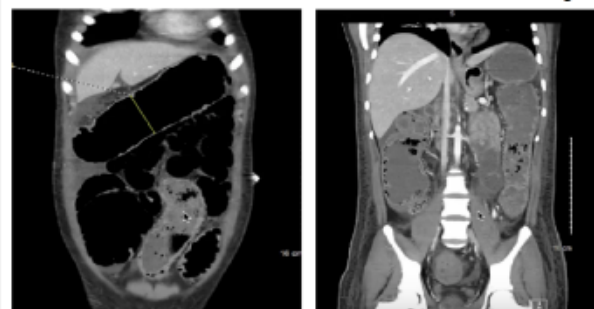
Axial computed tomography (CT) scans. Findings are worrisome for fulminant colitis resulting in toxic megacolon
